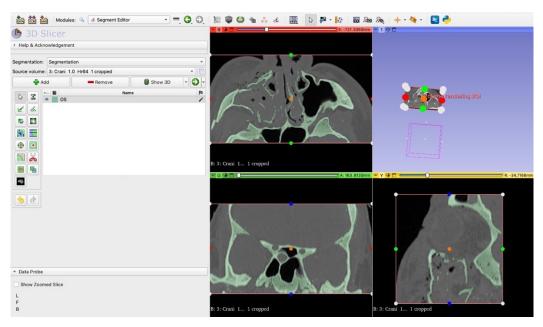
3D Slicer v5.6.1 software used for image segmentation showing a CT scan of an orbital fracture. Image taken by Alba Rodríguez.
